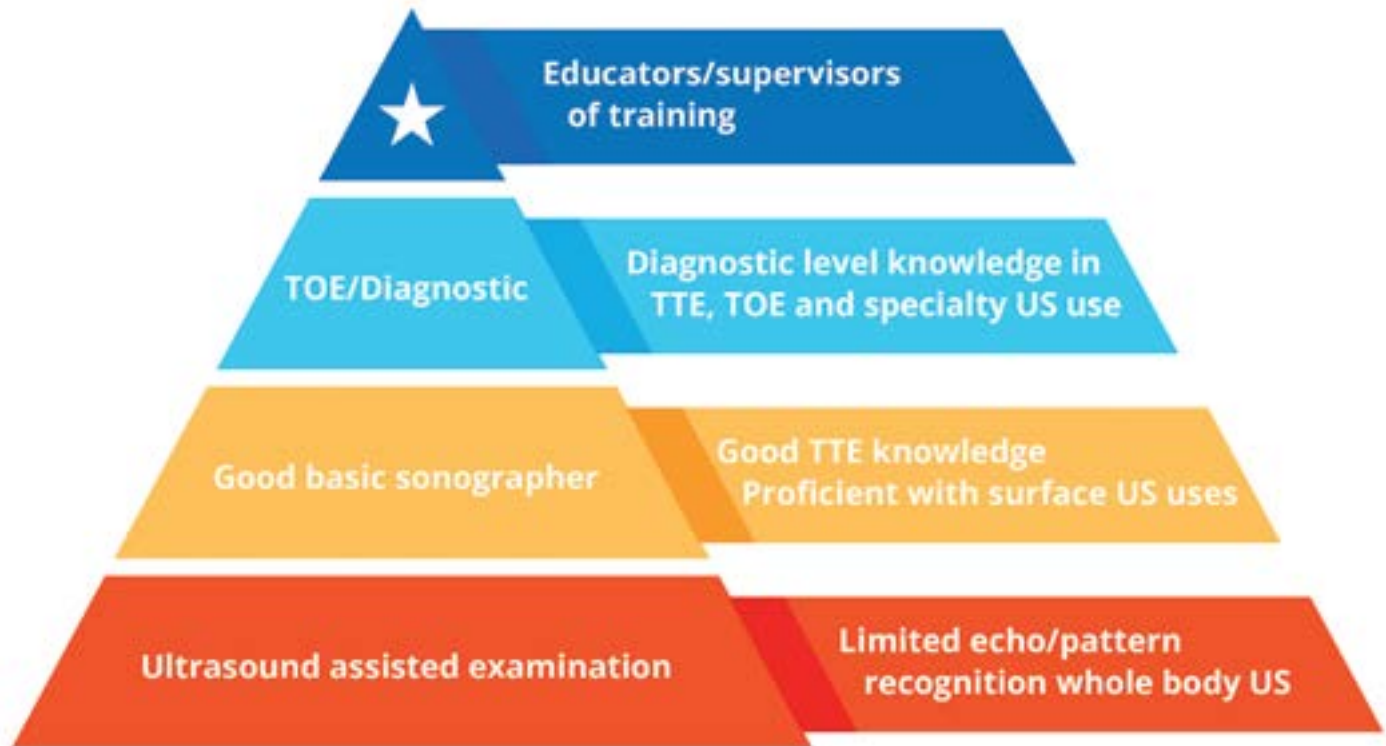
Ultrasound expertise pyramid
